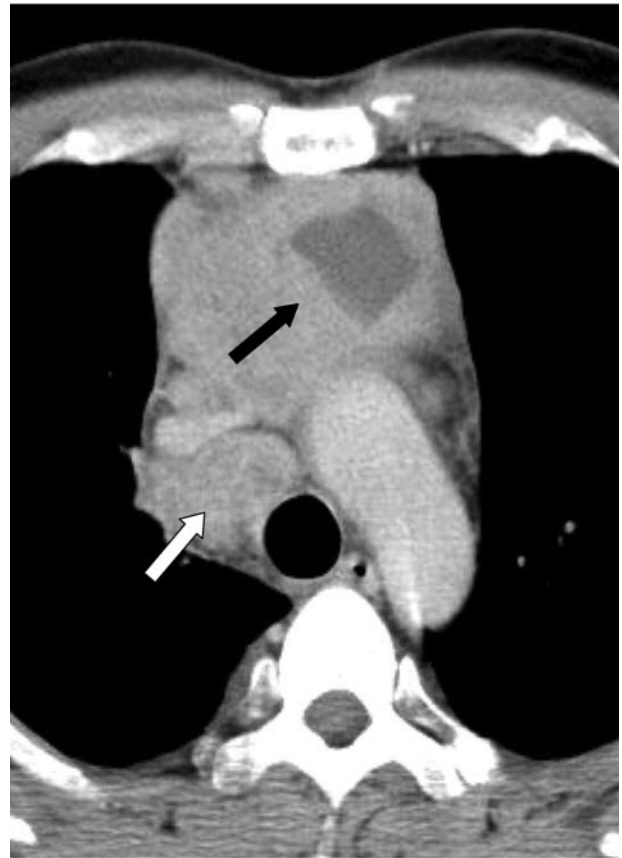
A 39-year-old man with nodular sclerosing HD. A contrast-enhanced CT scan shows an anterior mediastinal mass in which the central portion is cystic (black arrow). The right paratracheal lymph node is enlarged (white arrow).
